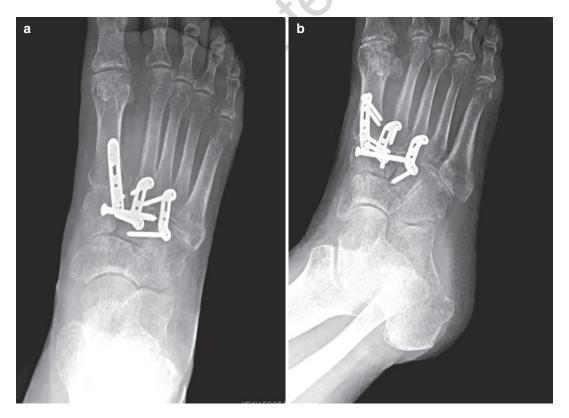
AP (a) and oblique (b) plain films following partial arthrodesis of the Lisfranc joint
